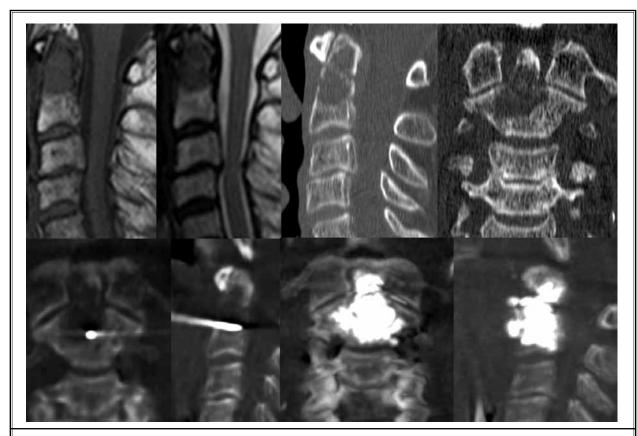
(left to right) Magnetic resonance and computed tomography with 2 dimensional reconstruction pre-procedural evaluation confirmed osteolytic lesion at C2 and did not reveal any lesion or compression to the spinal cord. Procedural CT confirmed needle placement within the lesion allowing satisfactory bone cement injection (lower left to right).
